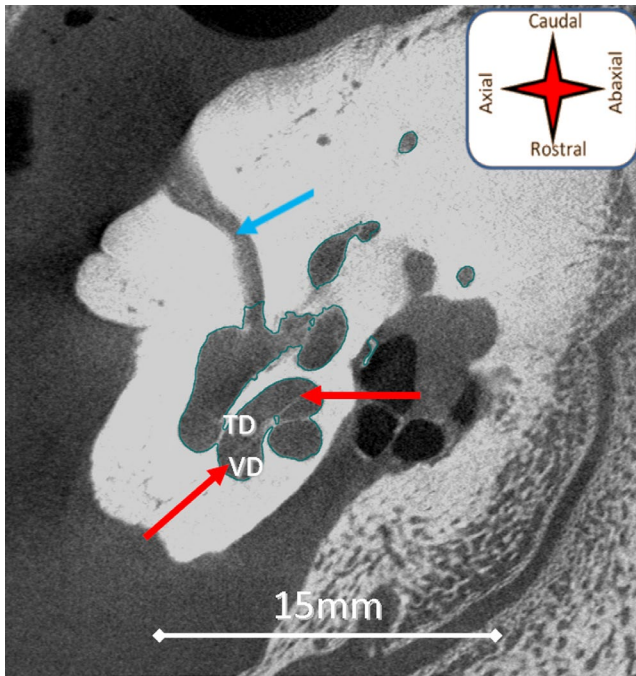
Micro-focus X-ray computed tomography 2D slice image obtained from the left ear of case 2, coronal plane. The tympanic (TD) and vestibular (VD) ducts with associated osseous spiral lamina (red arrows) are visible in the cochlea. The cochlear aqueduct is also clearly visible (blue arrow)
